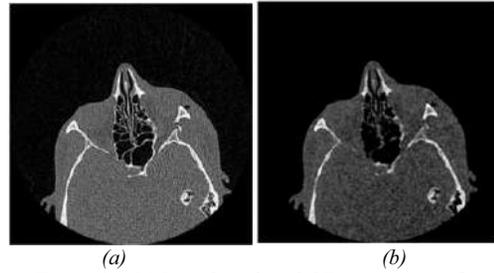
(a) Low-dose dental CT noisy image. (b) Resulting image K after the opening operator.
